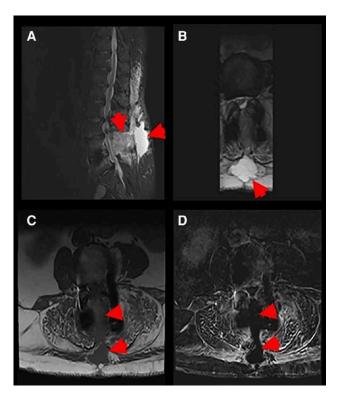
MRI findings in early postoperative infections. Sagittal STIR (*A*), axial T2-weighted (*B*), axial unenhanced T1-weighted (*C*), and axial subtraction contrast-enhanced T1-weighted (*D*) images show a localized fluid collection posteriorly in the soft tissues at the L4/L5 level and a non-liquified collection more anteriorly. There is mild surrounding contrast enhancement. Abbreviations: MRI, magnetic resonance imaging; STIR, short tau inversion recovery.
